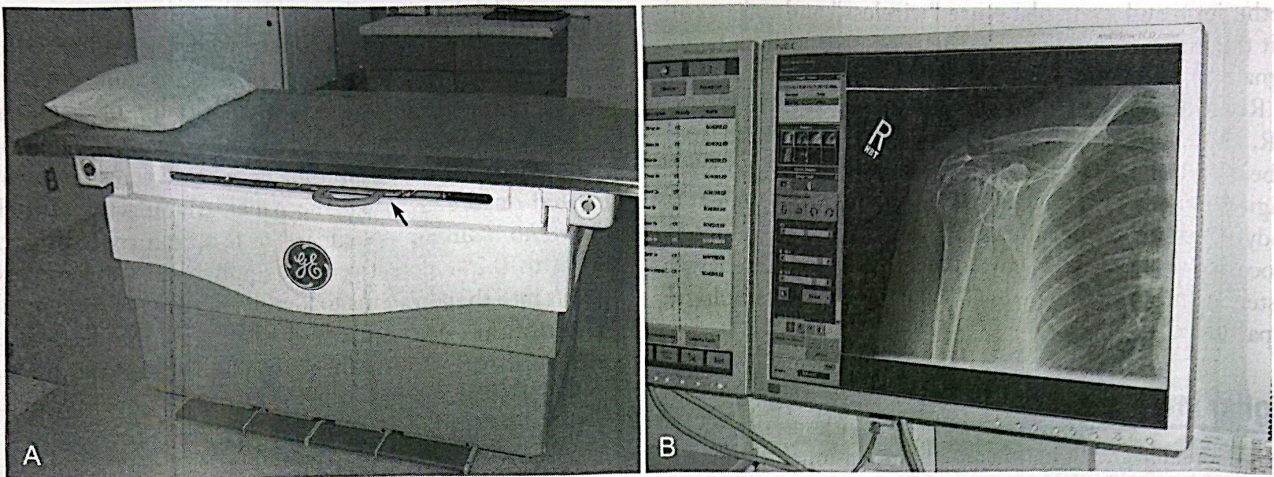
(A) Digital radiography x-ray table. The flat-panel detector unit is built into the table (*arrow*). There is no Bucky tray for either a conventional film cassette or a computed radiography (CR) imaging plate (IP). (B) The image is displayed on the monitor in the x-ray room in 3 to 5 seconds for viewing.
